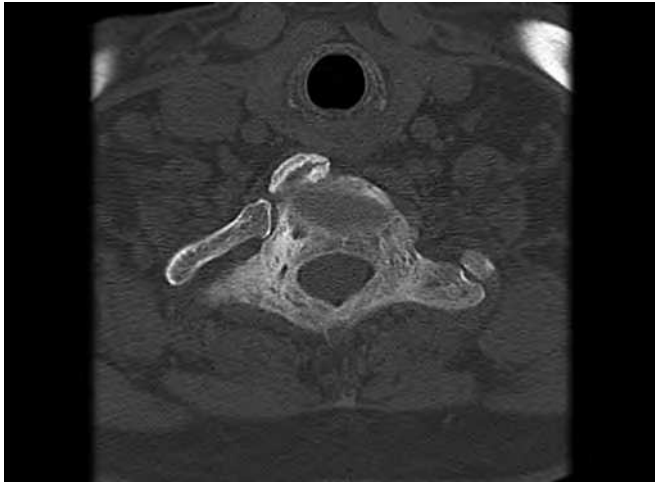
Axial CT thru T1: coarse trabeculation with enlargement of the pedicles and posterior elements (CT: Computed tomography).
